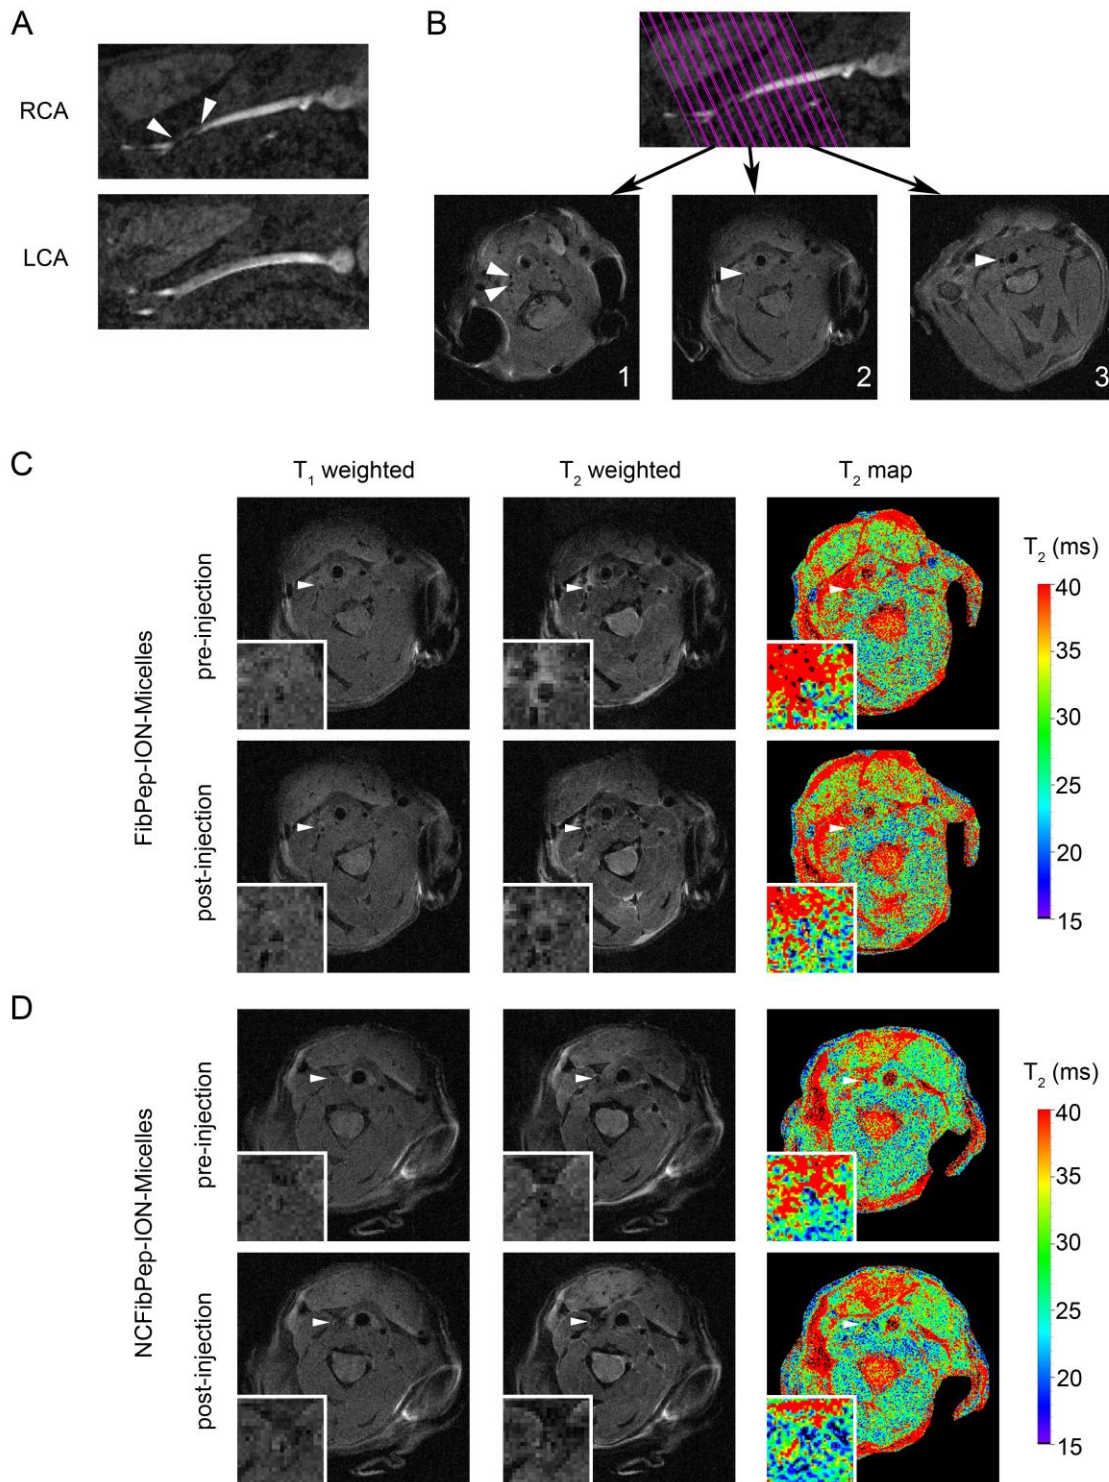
In vivo* MR images after thrombus induction. (A) Images of right and left carotid arteries (RCA & LCA) reconstructed from the 3D time of flight (TOF) image. The thrombus can be observed in the RCA just proximal of the bifurcation (arrowheads). (B) On the TOF image 13 parallel slices were planned perpendicular to the RCA. T_1 -weighted images from three slices are shown: (1) distal from the bifurcation, (2) in the thrombus and (3) proximal to the thrombus (arrowheads: RCA). (C, D) Pre and post injection T_1 - and T_2 -weighted images and T_2 maps of (C) FibPep-ION-Micelles and (D) NCFibPep-ION-Micelles (arrowheads: RCA). The insets show magnifications of the RCA.
